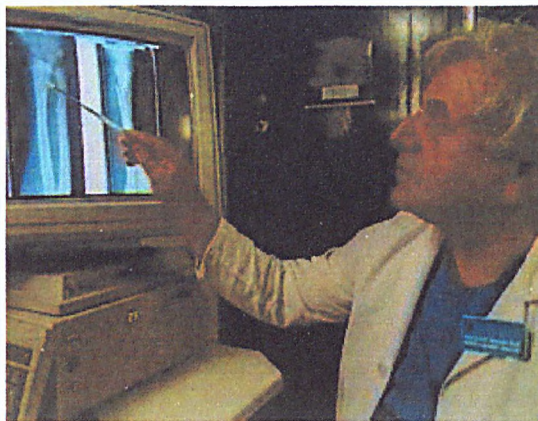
Examination of transmitted radiograph by A&E consultant.
